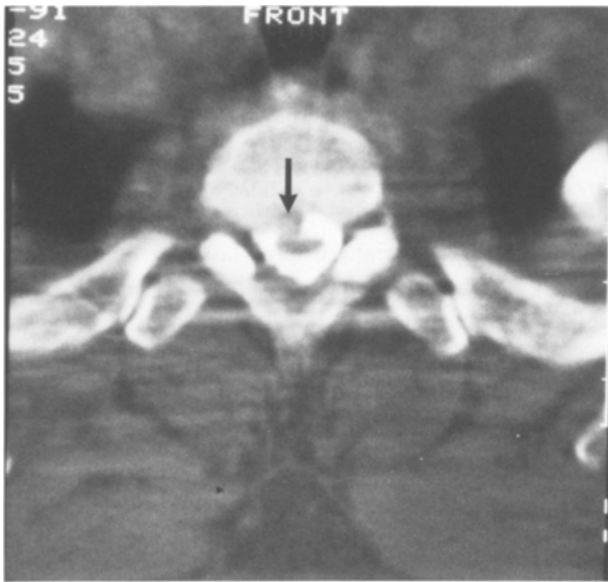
Post-myelography-CT scan from the same patient as in Fig. 1, showing a break in the contrast material (arrow). An intraspinal ventral epidural space-occupying lesion can be visualized and was proven intra-operatively
